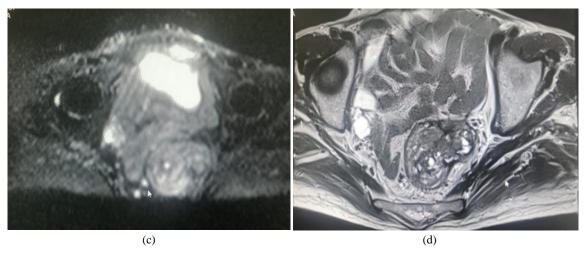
Abdominal imaging demonstrates a mass evolving in the upper and middle rectum, 8 cm from the anal margin, measuring 57x42x63 mm, budding at the level of the mesorectal fat (A,D) with conservation of the anal canal (B), with multiple nodules of the mesorectum (as shown in the diffusion sequence of the pelvic MRI) (C).
